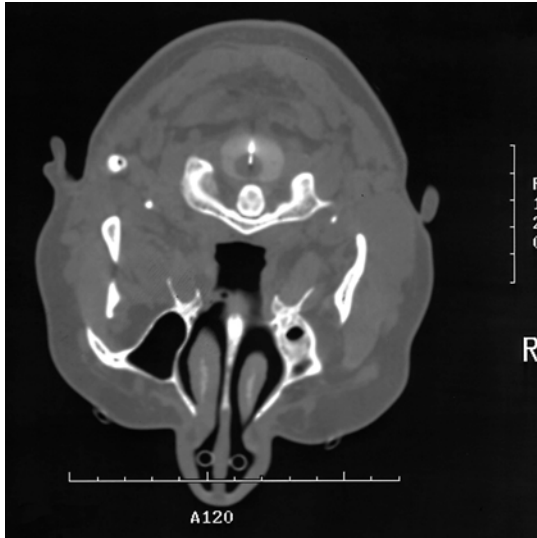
Final position of the electrode on axial CT scan at occiput-C1 level in extra-lemniscal myelotomy
